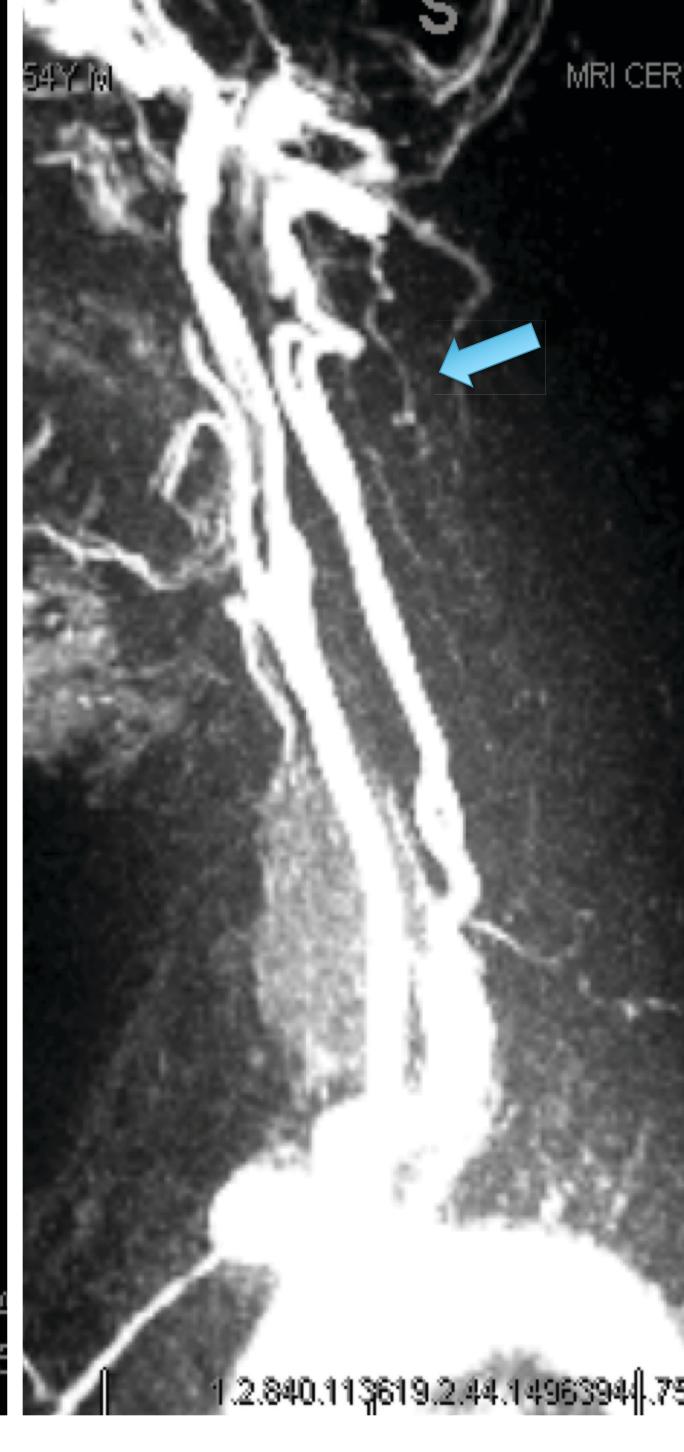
MRI cervical spine: Spinal veins filling from arteriovenous fistula
